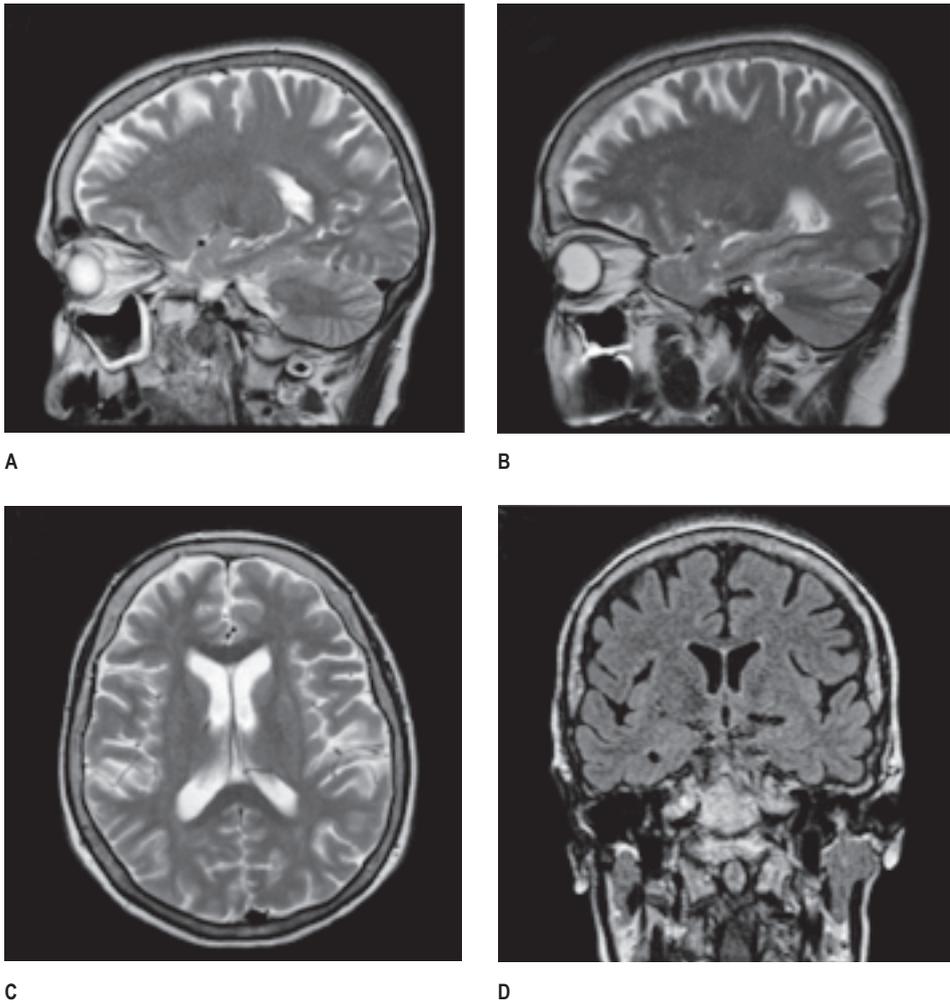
MRI of the brain: A – sagittal T2-weighted image of the left hemisphere; B – sagittal T2-weighted image of the right hemisphere; C – axial T2-weighted image; D – coronal FLAIR image
